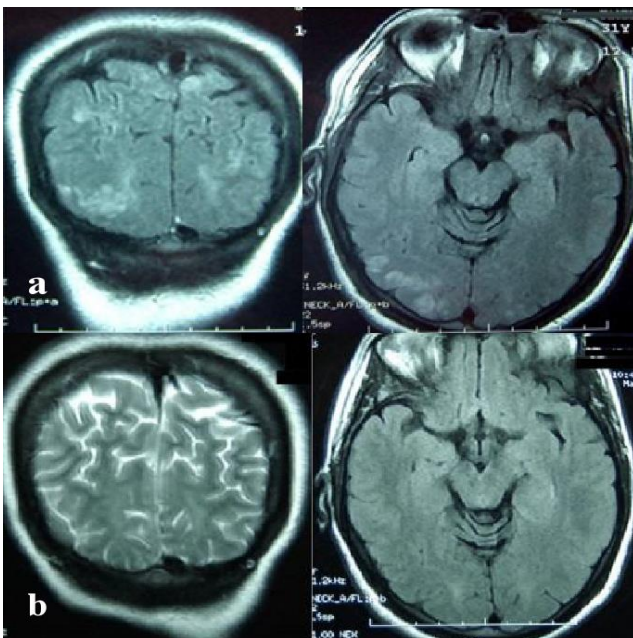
(A and B): Brain magnetic resonance imaging (MRI), axial and coronal section, FLAIR sequence: bilateral and asymmetric cortico-subcortical hypersignals, in parieto-occipital area and the 2 months brain MRI control: complete resolution of the brain damages.
